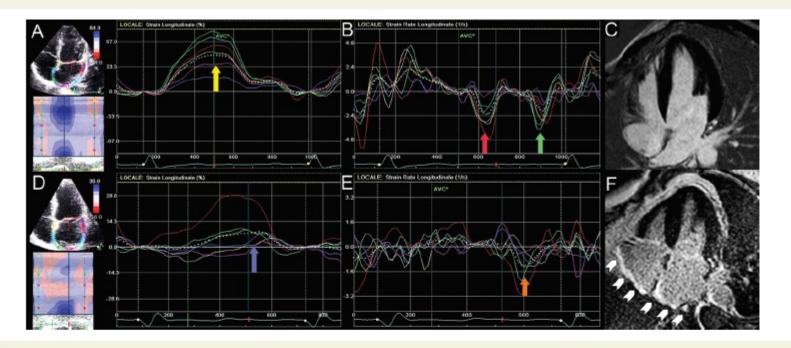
Figure I Transthoracic echocardiography in the four-chamber view showing global left atrial (LA) longitudinal strain in a normal subject. The positive peak (yellow arrow) represents an atrial preserved reservoir phase, which occurs during ventricular systole (A). Transthoracic echocardiography in the four-chamber view showing global LA longitudinal strain rate in a normal subject. During ventricular diastole it is possible to identify two negative peaks, the first corresponding to passive early LV filling (red arrow) and the second to atrial booster pump function (green arrow) (B). Cardiac magnetic resonance imaging in the four-chamber view showing a normal heart with no atrial delayed contrast enhancement and normal atrial volumes (C). Transthoracic echocardiography in the four-chamber view showing global LA longitudinal strain in a patient with permanent atrial fibrillation (AF). A reduction of positive curve during the reservoir phase (purple arrow) is expected in a patient with reduced LA compliance (D). Transthoracic echocardiography in the four-chamber view showing global LA longitudinal strain rate in the same patient. Loss of left atrial booster pump function occurs and a single negative deflection (orange arrow) can be observed during ventricular diastole, as the main pattern of AF (E). Cardiac magnetic resonance imaging in the four-chamber view showing delayed contrast enhancement in both atria (white arrow heads) and atrial dilatation in the same patient with permanent AF (F).
